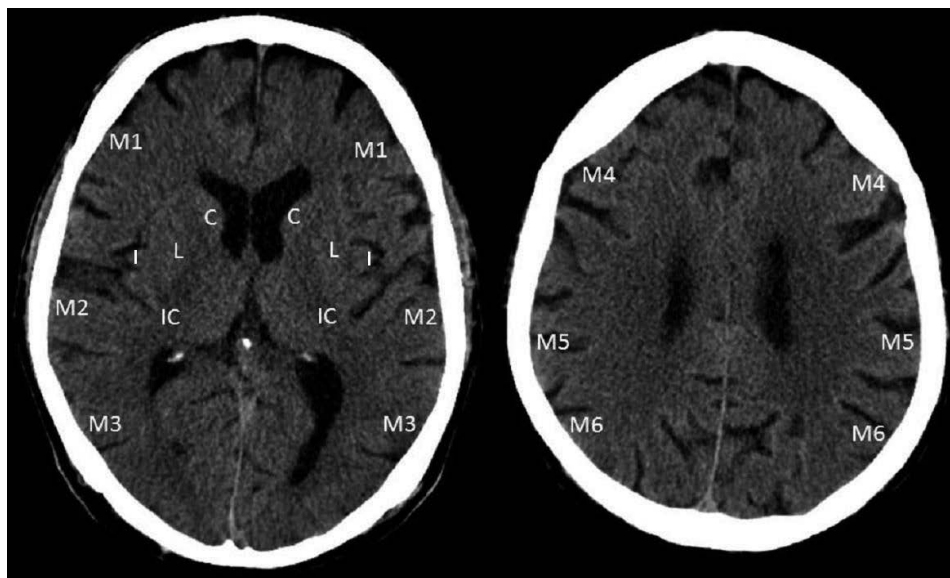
Extent of MCA vascularisation on both sides with marked areas, enabling assessment of ischaemic lesions on ASPECTS scale. Markings as follows: Alberta Stroke Programme Early CT Score (ASPECTS) – a scale used to quantify early ischaemic changes in CT, where C – caudate nucleus; L – lenticular nucleus; I – island; IC – inner capsule; M1 – anterior cortical area part frontal lobe; M2 – cortical area lateral to island ribbon; M3 – posterior cortical area temporal lobe; M4 – anterior area located above M1 area; M5 – central area located above M2 area; M6 – posterior area located above M3 area
